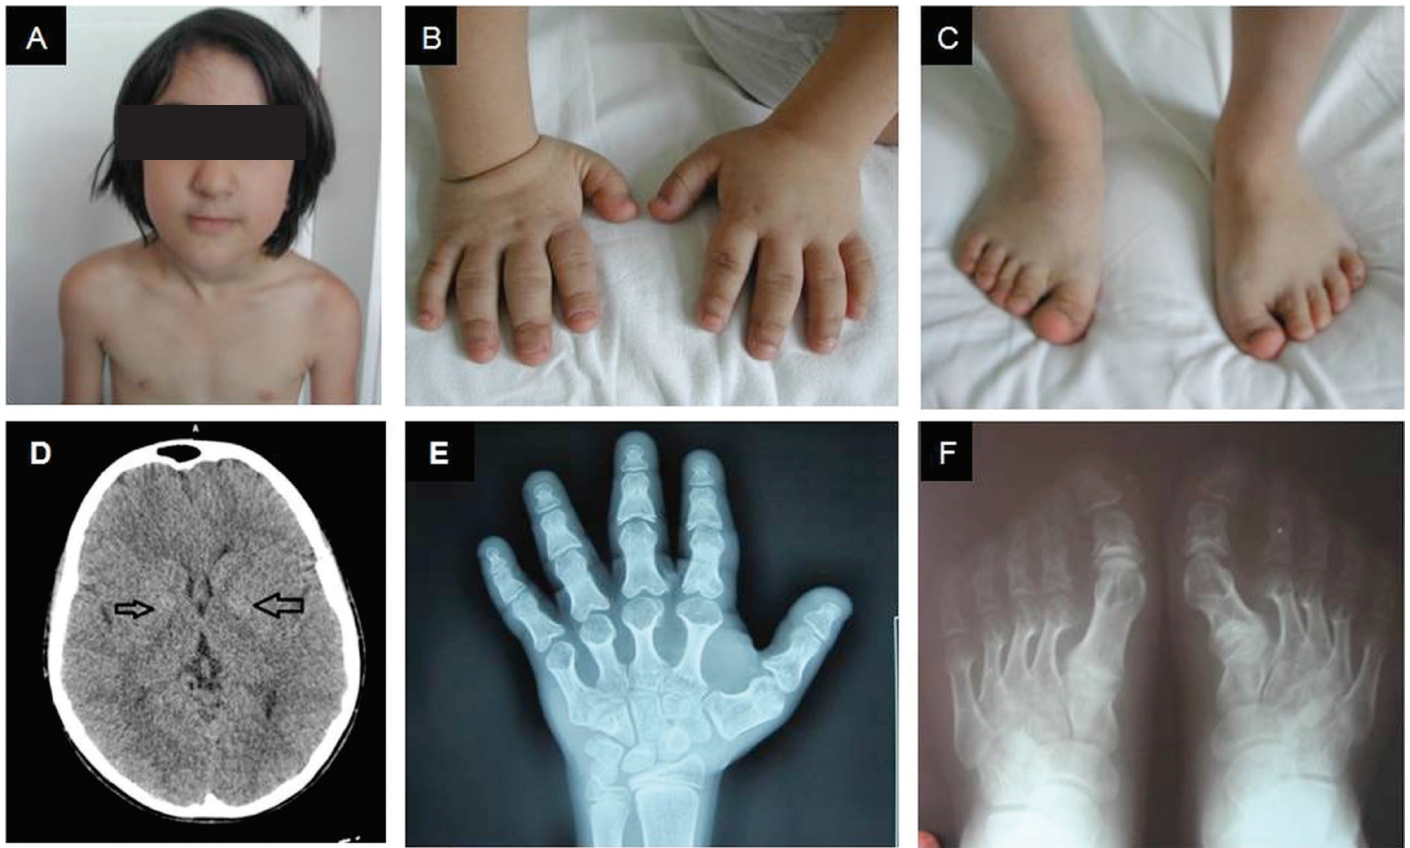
The photograph of the patient at age 7 years. Note round face, full cheeks, and short neck (A). Short hands and feet (B, C). Cranial computerized tomography showing bilateral calcification of globus pallidus (D). Roentgenogram of hands and feet. Marked shortness of metacarpals and metatarsals (especially 4th and 5th). (E, F) Cone-shaped epiphyses are visible in all tubular bones of hand
